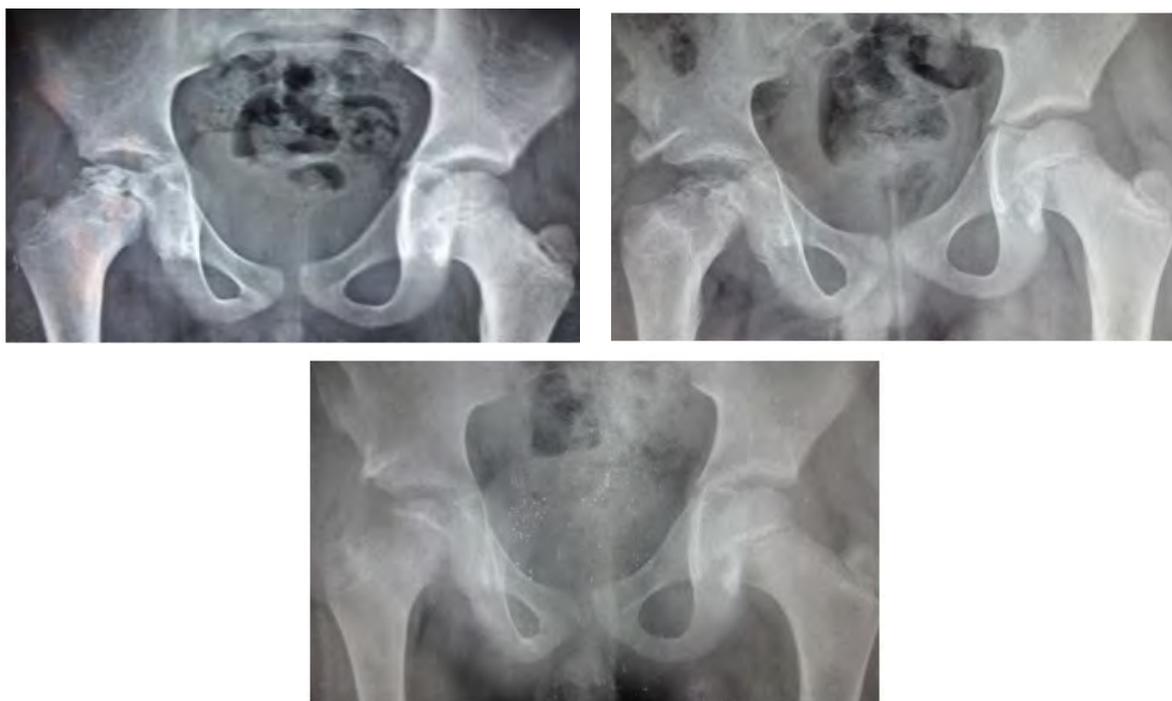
(a) Pre op X-ray. (b) Immediate post op X-ray. (c) X-ray at 2 years with satisfactory result (Stulberg 2).
